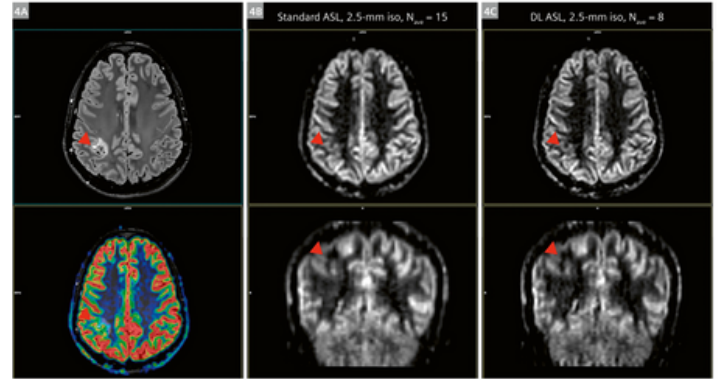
Epilepsy case (34-year-old female). The red arrow points to the cortical seizure area where a DNET tumour has formed, which shows a hypoperfusion pattern in the ASL-derived perfusion maps. Panel (4A) shows the axial view of the 3D T2 FLAIR (top) and the overlaid perfusion map (bottom). Panel (4B) shows the acquired 2.5-mm isotropic mean perfusion-weighted map in both axial (top) and coronal (bottom) views. Panel (4C) shows the reconstructed 2.5-mm isotropic mean perfusion-weighted map after applying DL algorithms.
